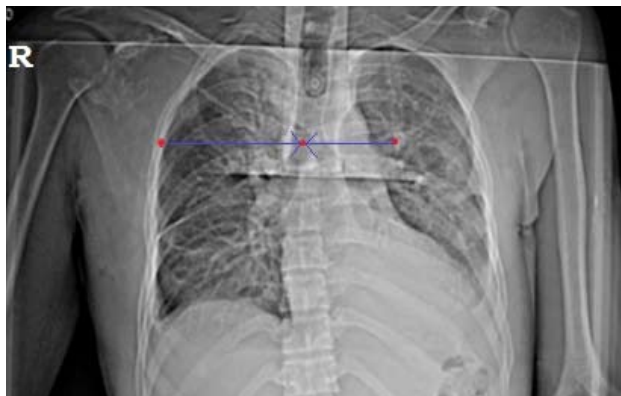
Radiograph showing lateral displacement of the scapula which can be quantified by the scapular index. The distance from the spinous process to the medial border of the scapula is measured bilaterally. The value of the injured side is divided by the value of the non-injured side.
